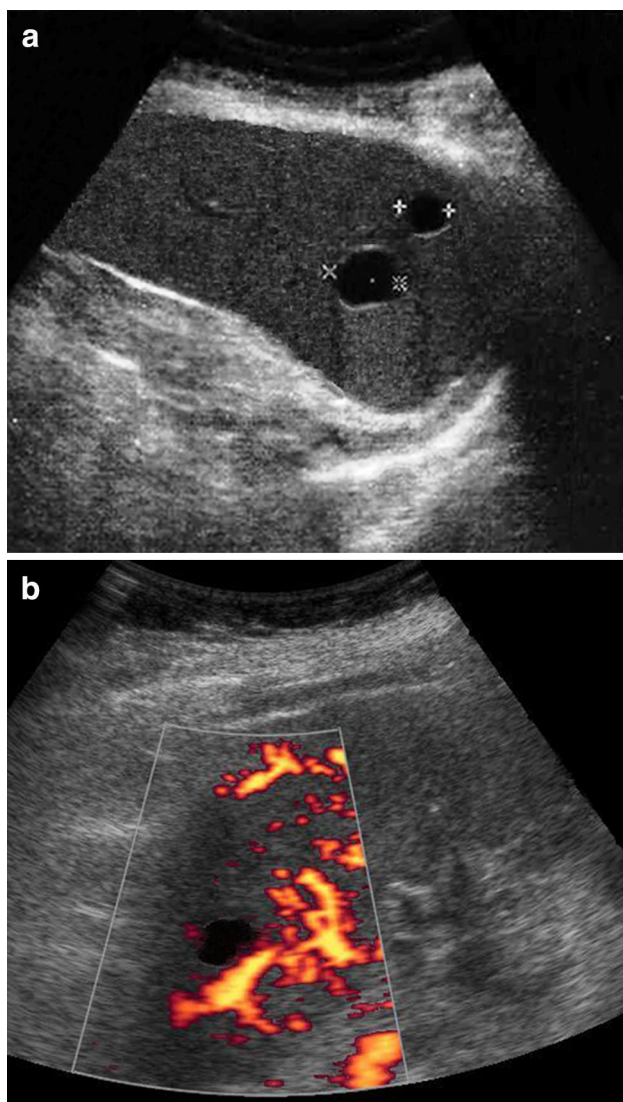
US findings (left intercostal oblique scans). a B-mode US. Two round, anechoic lesions with distinct boundaries, smooth discontinuous thin wall, posterior echo enhancement, and lateral shadowing were found in the upper splenic pole. Spleen size was normal (bipolar diameter 11.8 cm). b Power Doppler US. The lesions showed no vascular signals
